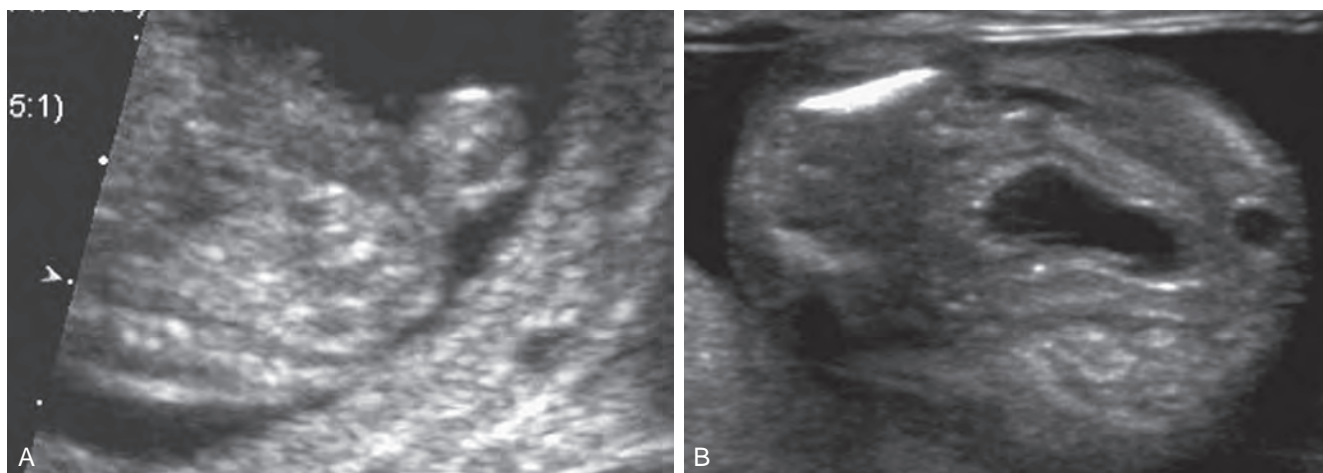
Ultrasound image of megalourethra in a male fetus at 15 weeks' gestational age. A, Sagittal view of dilated penile urethra. B, Transverse view showing thick-walled bladder and dilated posterior urethra in perineum.
